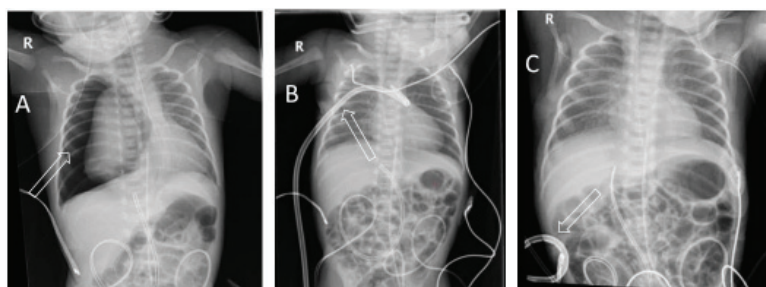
A: Chest x-ray showing right-sided pneumothorax (open white arrow)
